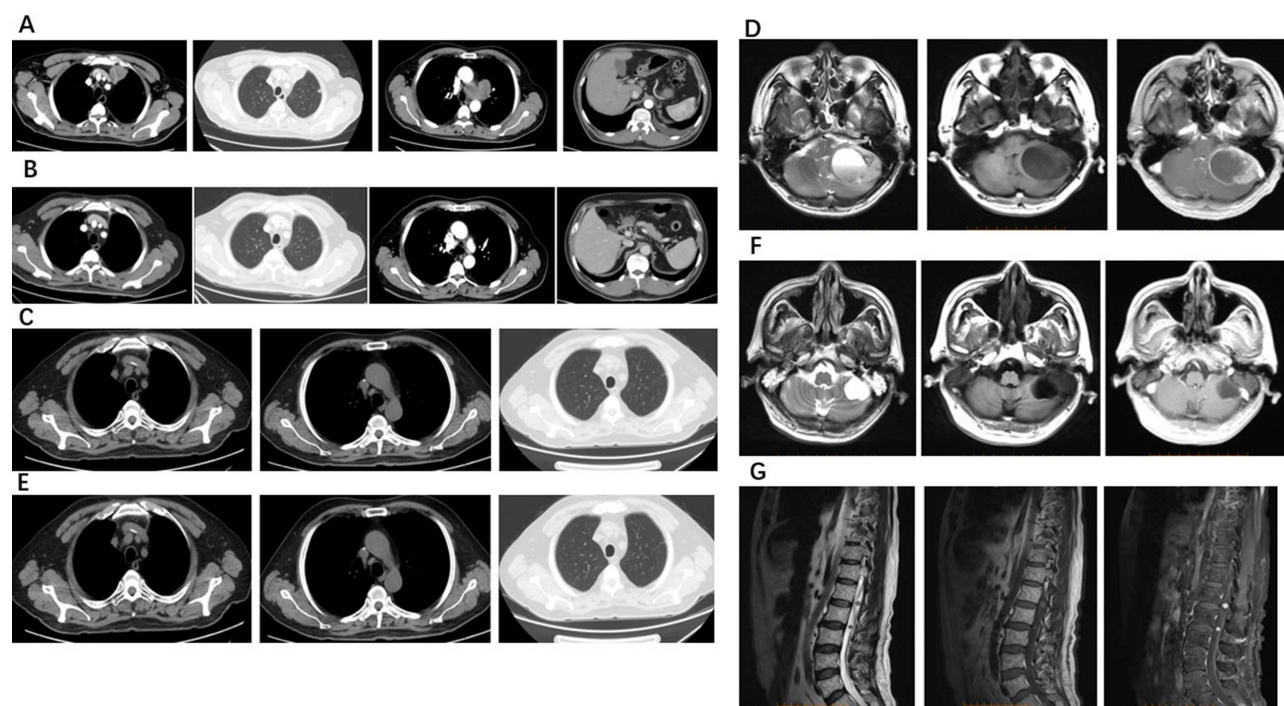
Baseline before immunotherapy. (A) 4 cycles after immunotherapy. (B) February 2021, chest CT before cystic brain metastasis. (C) March 2021, cystic brain metastasis. (D) April 2021, chest CT SD. (E) September 2021; 6 months after cystic brain metastases occurred. (F) March 2022, spinal metastasis. (G).
